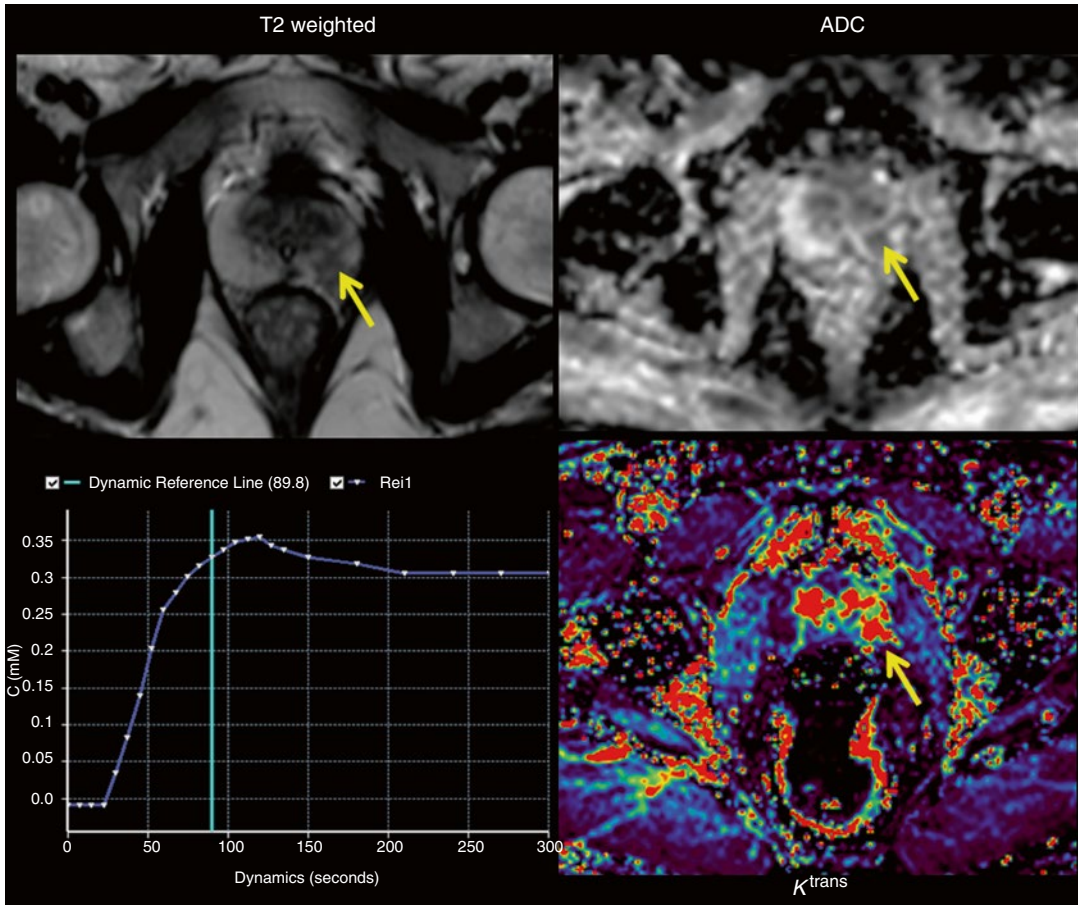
Prostate cancer. Small nodule hypointense on T2-weighted sequence on left peripheral zone demonstrates low ADC values and increased K^{trans} value, indicating a high-grade tumor (arrows)
